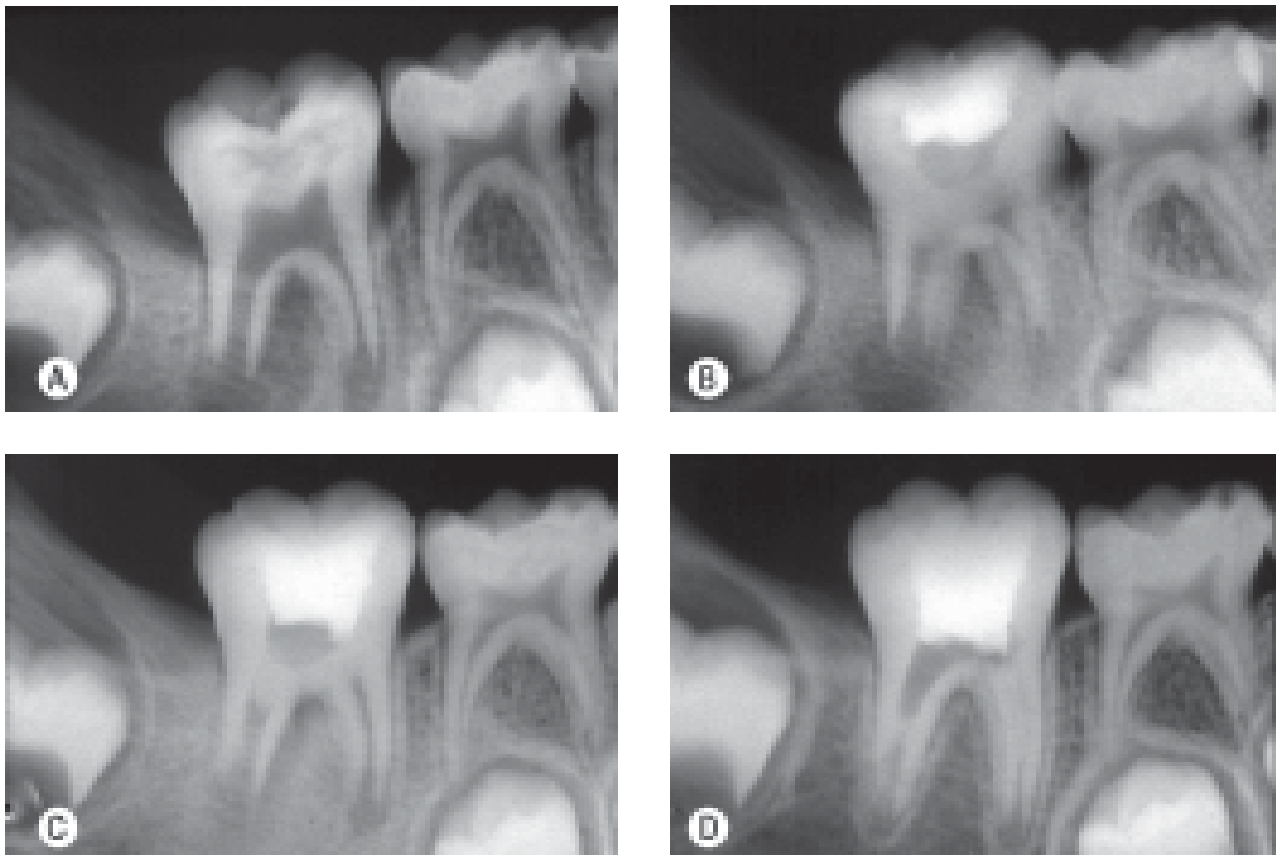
Radiographic follow-up of a pulpotomized immature permanent mandibular right first molar with vital pulp. (A) Preoperative periapical radiograph showing furcation lesion communicating with a periapical lesion on the distal root. (B and C) Radiographic aspect after calcium hydroxide pulpotomy (note that the deeper level of pulp amputation in the distal root). (D) Nine-month control radiograph, showing resolution of the furcation and periapical lesion and normal root development.
